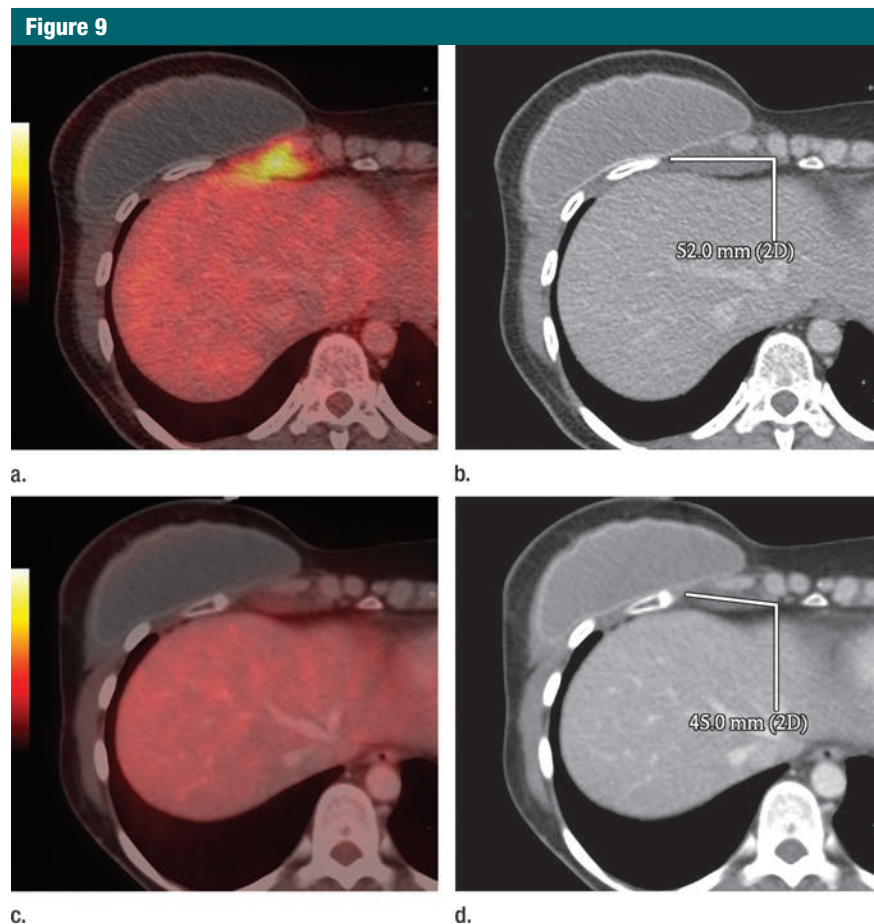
Same patient as in Figure 8. (a) Axial PET/CT fusion image shows high FDG uptake, which is suggestive of recurrence behind the breast prosthesis. (b) Axial CT image from PET/CT examination shows soft-tissue mass with a long axis of 52 mm. This recurrence behind the breast prosthesis was not reported before PET/CT. (c) Axial PET/CT fusion image shows that, after chemotherapy, FDG uptake no longer was visible behind the prosthesis. (d) Axial CT image shows persistent mass with long axis of 45 mm (–13% in comparison with 52 mm in the pretreatment image). 2D = two-dimensional measurements in one plane.
